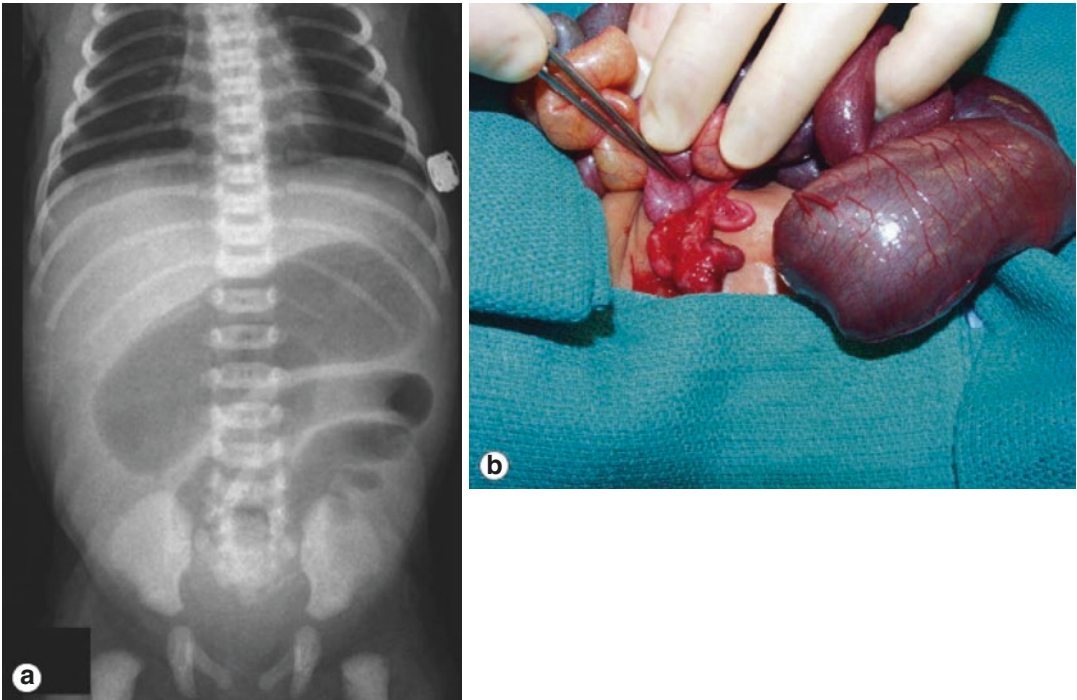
Radiographic and intraoperative findings of jejunal atresia [14]
